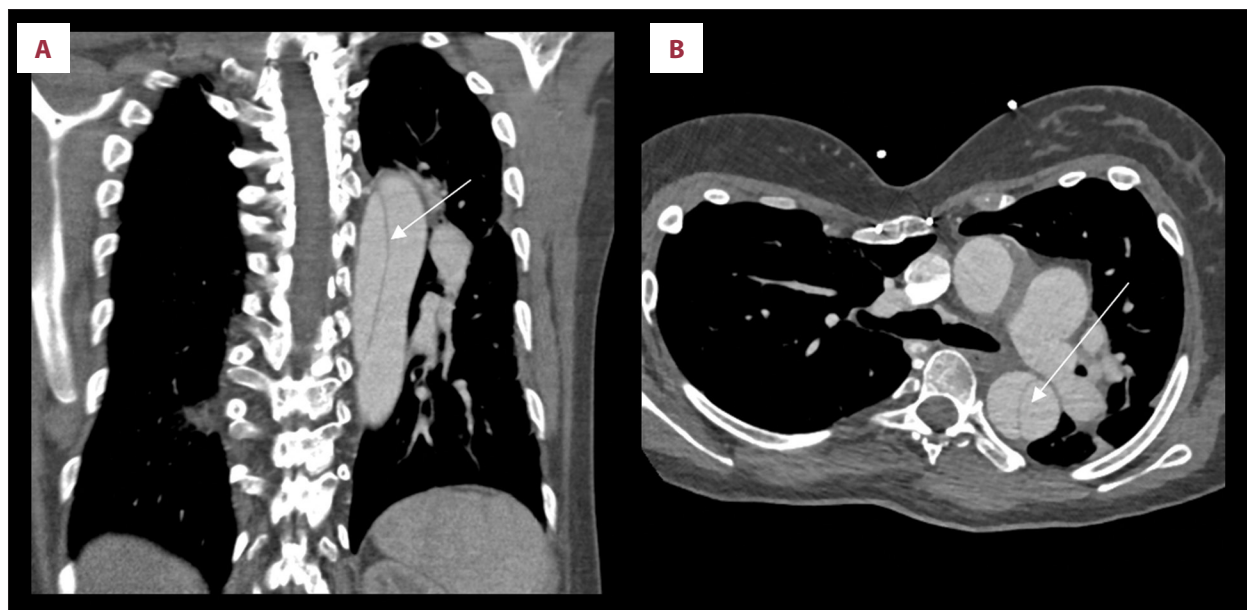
Computed tomography angiography: signs of the dissection membrane (arrow) of the descending aorta in frontal (A) and transversal view (B). True and false lumens are equally contrasted.
